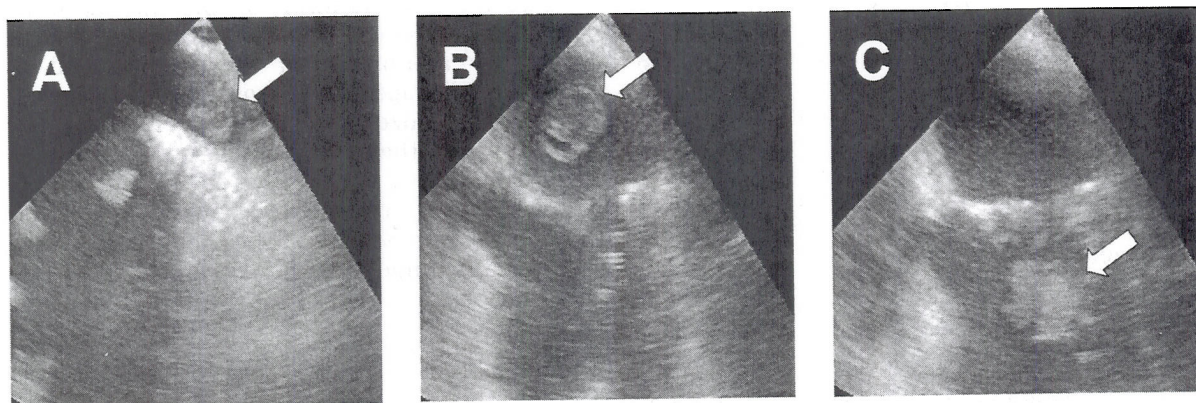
Transesophageal echocardiographic images selected from a 5-second sequence obtained in a patient undergoing off-pump coronary artery bypass grafting (CABG). Arrows indicate a clot noted in the (A) left atrial appendage that became mobile during the procedure, which was then seen in the (B) left atrium, and subsequently in the (C) left ventricle.
